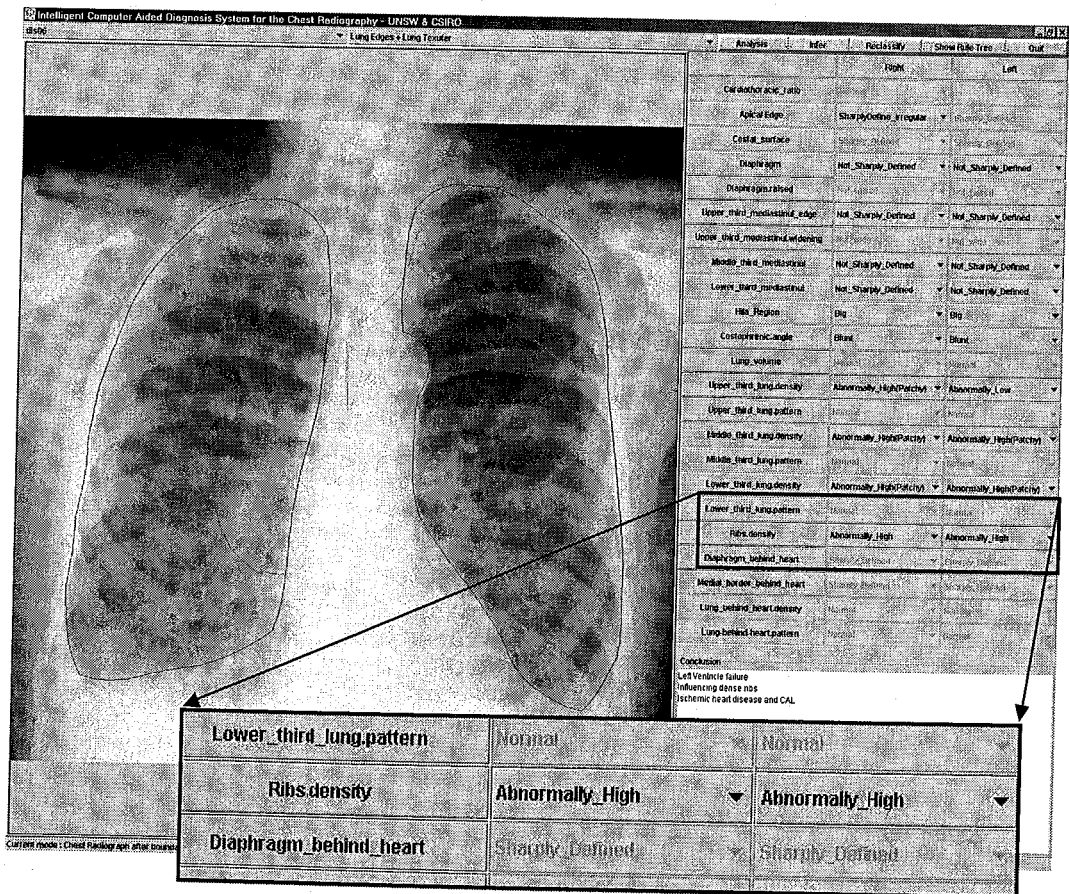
Computer Aided Diagnosis System for chest Radiographs
